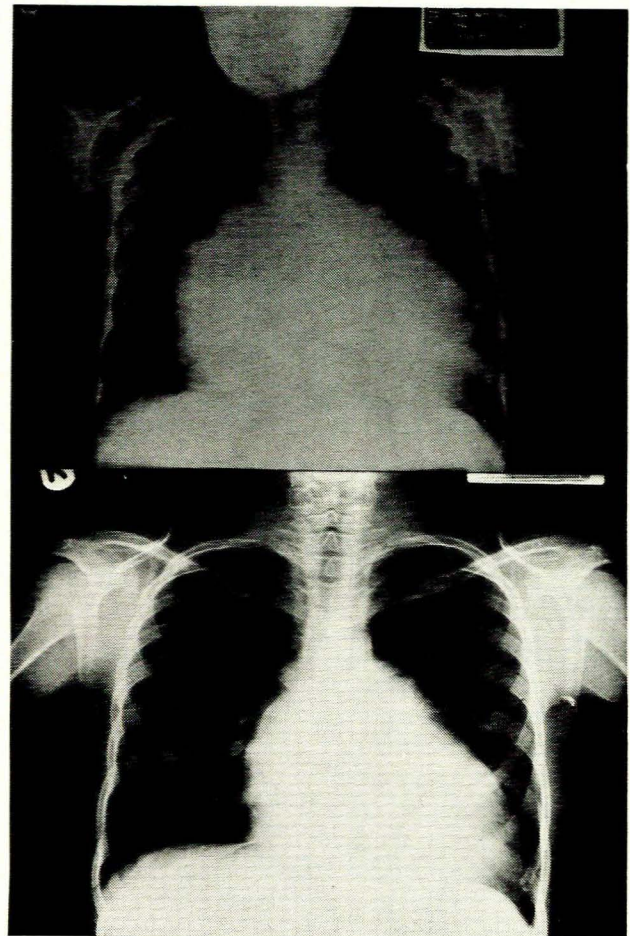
Case 3. Pre- and postoperative X-ray studies.
